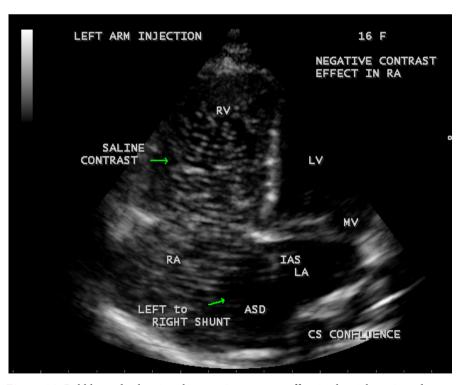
Bubble study showing the negative contrast effect in the right atrium due to left to right shunt through a secundum defect in apical four chamber view.
